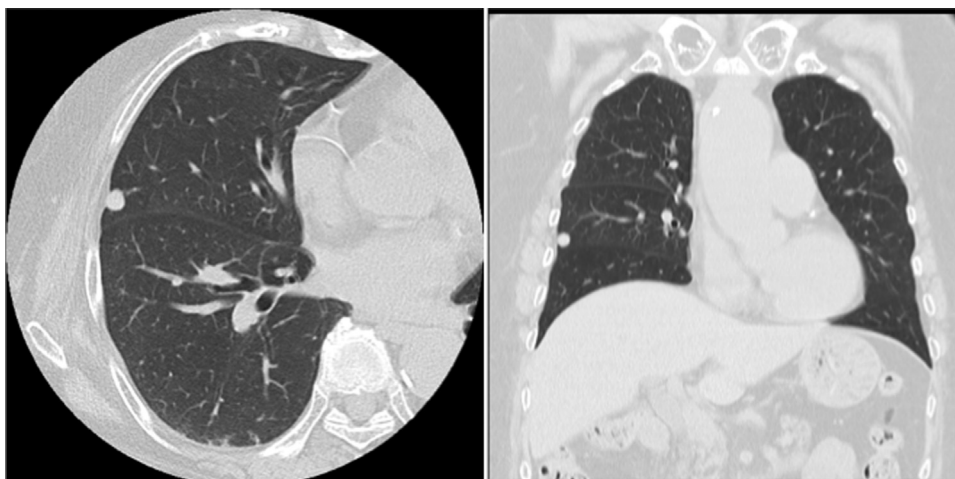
Transverse and coronal chest CT images show a growing pulmonary nodule in the right middle lobe.
